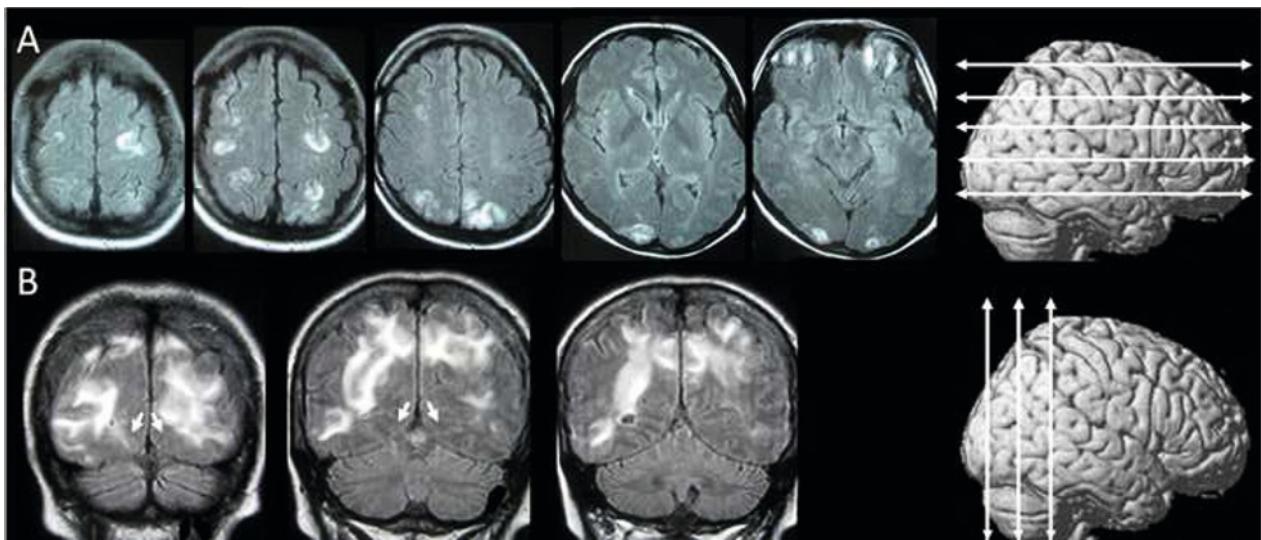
A. Axial FLAIR sequences showing subcortical and cortical multifocal hyperintensities in the bilateral frontal, parietal, and occipital regions in a 24-year-old woman with RPLS associated with hypertension and eclampsia. B. Posterior-located, mainly subcortical, hyperintense lesions on coronal FLAIR imaging with an asymmetrical distribution (right hemisphere more involved than the left one) in a 67-year-old patient with RPLS associated with immune globulin therapy and hypertension. Arrows point to the calcarine sulcus (striate cortex) which is relatively spared. The side view of the brain gives an approximate indication of the level at which the axial and coronal sections are taken.
